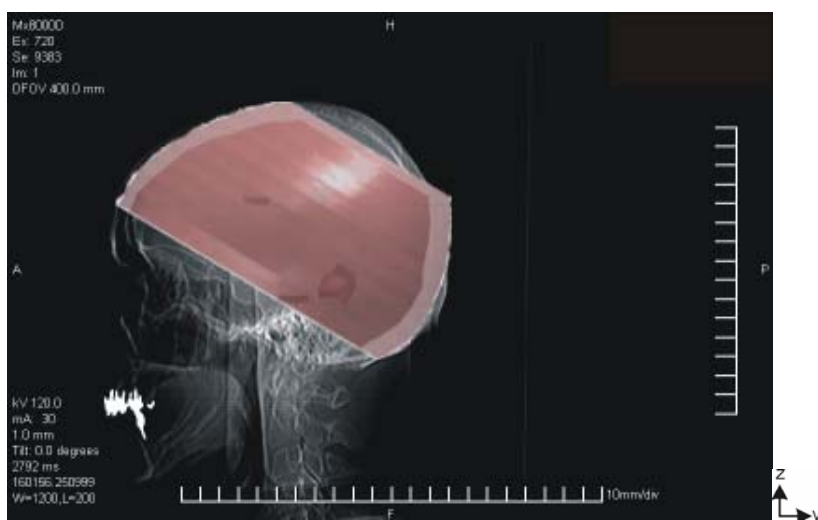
CT image in sagittal plane with yz projection of the modelled 3D geometry.
